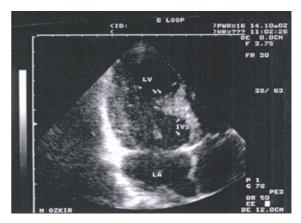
Two dimensional echocardiogram in apical four chamber view: focal hypertrophy of the interventricular septum with a mass-like potrusion towards the left ventricular cavity (LA: Left atrium, LV: ventricle, IVS: Interventricular septum.
